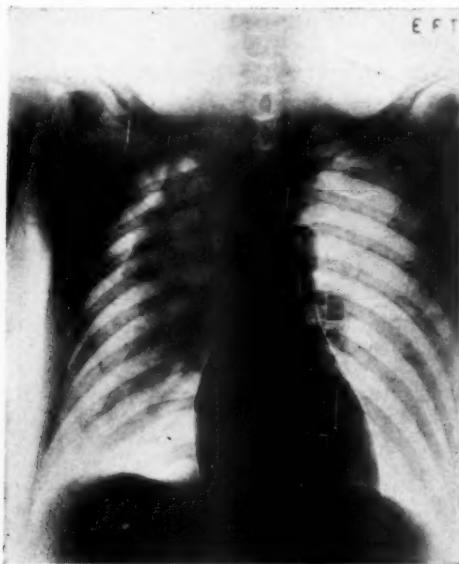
Case 2. Roentgenogram showing collapse of right lung due to injection of 1000 c.c. of nitrogen. Lower lobe quite collapsed.
